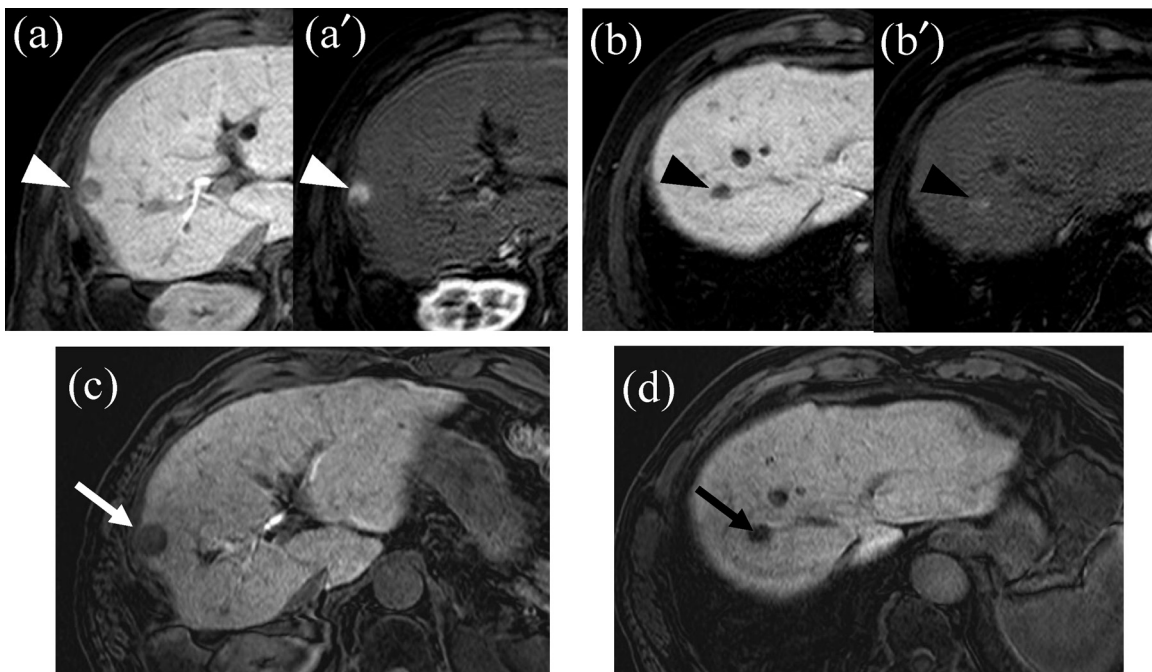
Contrast-enhanced magnetic resonance image (MRI) showing two new lesions with perfusion defect at the hepatic cell phase and good enhancement at the arterial phase. The white arrowhead indicates the 16-mm tumor near the border of segment 8 (a: hepatic cell phase, a': arterial phase). The black arrowhead indicates the 10-mm tumor below the hepatic dome in segment 8 (b: hepatic cell phase, b': arterial phase). The follow-up MRI scan obtained 3 months later shows that the tumor near the border of segment 8 had grown to 20 mm (c: white arrow) and that the lesion below the hepatic dome had grown to 17 mm (d: black arrow).
